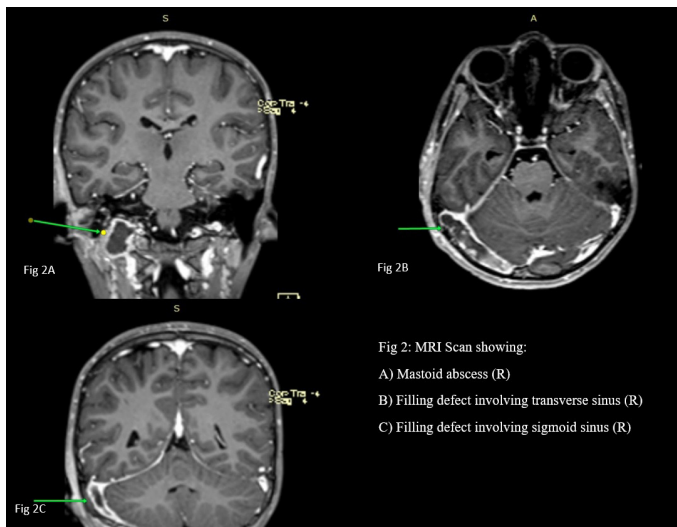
MRI Scan showing:
